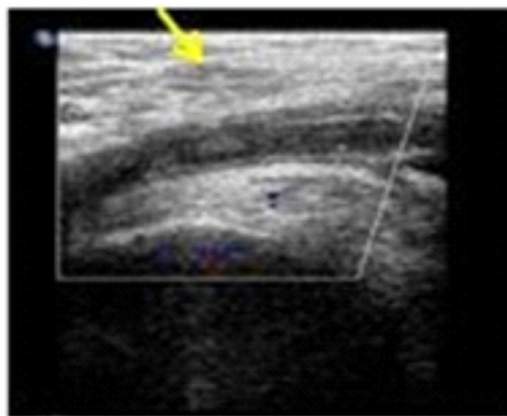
Venous Doppler of left common femoral vein demonstrating thrombus (hyperchoic) (yellow arrow) Fig 1b. CT pulmonary angiography demonstrating thrombus in right pulmonary artery. (yellow arrow)
